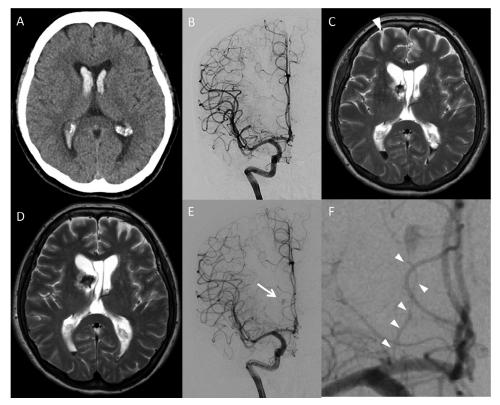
Preoperative follow-up imaging. (A) Initial computed tomography showing IVH occupying symmetrically bilateral lateral ventricles. (B) The DSA of the right internal carotid artery demonstrating no evidence of abnormal vessels including aneurysms, arterial dissections, or arteriovenous malformations. (C) The MRI on Day 12 revealing that a 8.0×9.0 -mm intraventricular mass emerged on the side of the head of the right caudate nucleus, which protruded into the right anterior horn. The right superior frontal sulcus was deep and close to the right anterior horn (arrowhead). (D) The MRI on Day 19 showing the size of the mass increased to 12×13 mm. (E) The DSA on Day 22 revealed pooling of the contract medium (arrow) arising from the right distal medial LSA. (F) The origin of the medial LSA (arrowheads) came from the right A1 segment. Abbreviations: DSA, digital subtraction angiography; LSA, lenticulostriate artery; MRI, magnetic resonance imaging.
